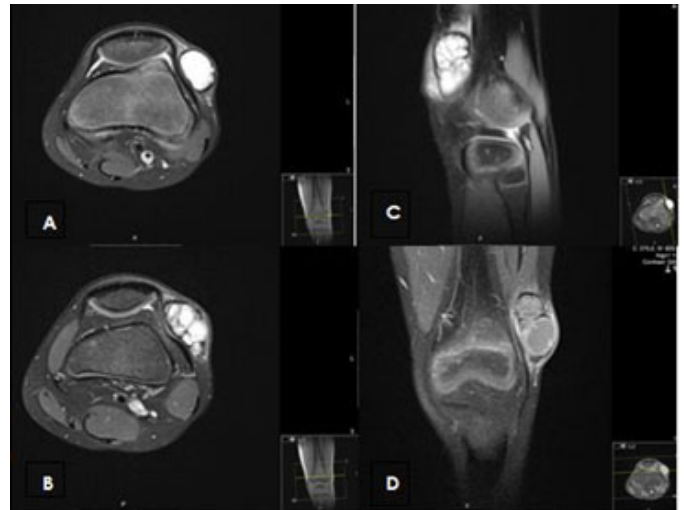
MRI study. (A) and (B) T2 axial reconstruction. (C) T2-sagittal reconstruction. (D) T1-coronal reconstruction.
